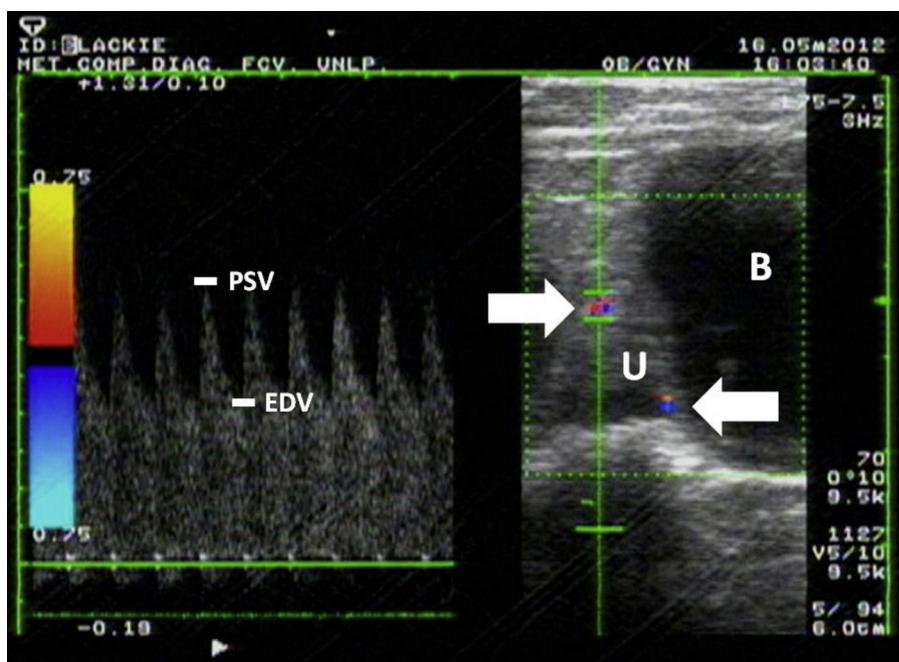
Pulsed wave Doppler ultrasound register of left and right uterine arteries (white arrows) at each side of the uterine body (U), in a selected pregnant queen 50 days after mating. Bladder (B); peak systolic velocity (PSV); end diastolic velocity (EDV).
